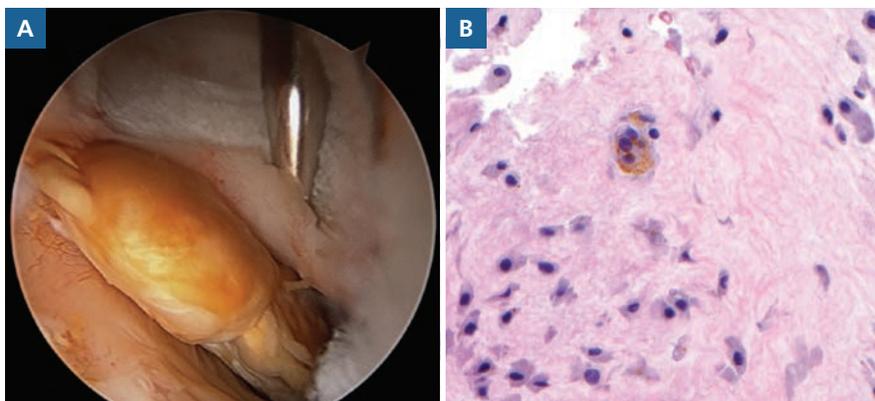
A, Arthroscopic image of a yellowish-red mass with frond-like projections consistent with hip PVNS in a 24-year-old woman with groin pain. B, A hemosiderin-laden macrophage is identified via a CT-guided core needle biopsy.
